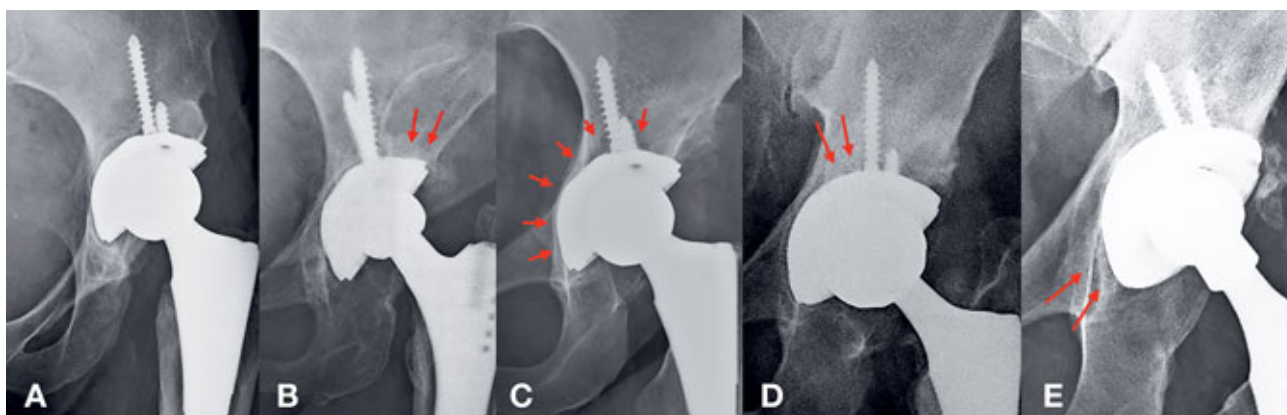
Five radiographic signs of osseointegration described by Moore et al.: A – absence of radiolucent lines, B – presence of a superolateral buttress, C – presence of medial stress-shielding, D – presence of radial trabeculae, E – presence of an inferomedial buttress.
